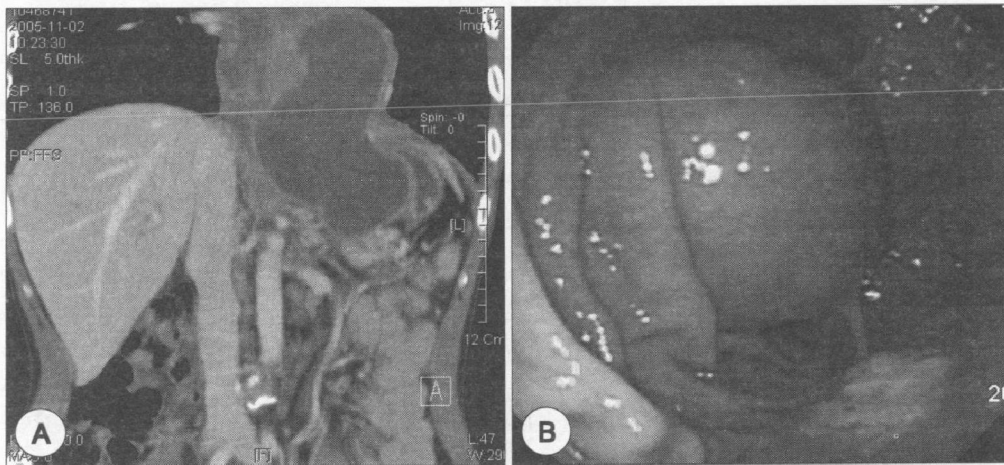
A : Abdominal CT vertical scan shows large cystic lesion measuring 8.7×9.9×15cm from pancreatic body extending to mediastinum. B : Endoscopic view shows a large extrinsic compression in the gastric cardia.
